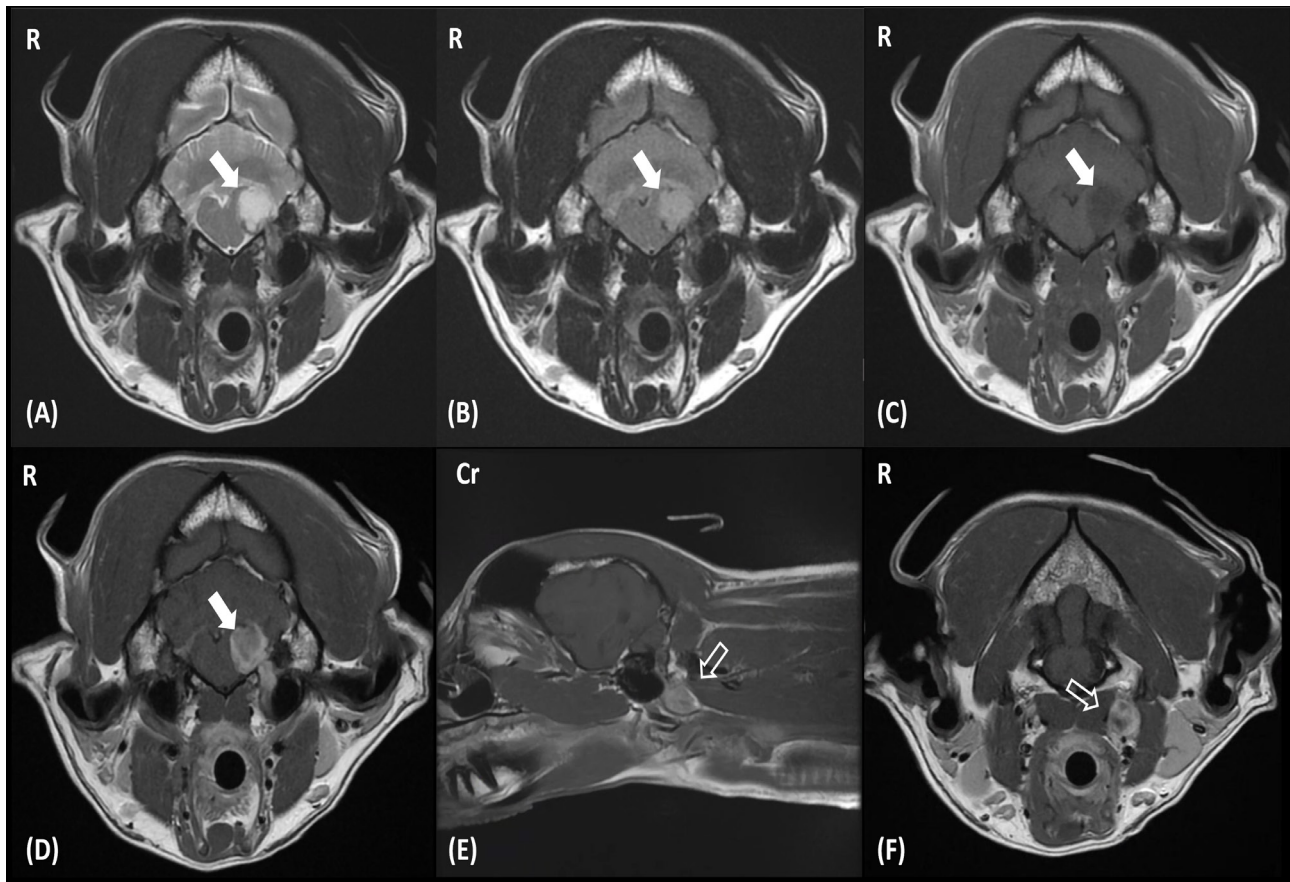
Magnetic resonance imaging of the intracranial and extracranial lesion. Left side corresponds to the right side of the patient. A well-demarcated mass (white arrows) was located at the left lateroventral region of the medulla oblongata and extended caudally and medially through the jugular foramen and tympano-occipital fissure, forming a tubular-shaped lesion. The lesion appeared hyperintense on T2-weighted (A) and FLAIR (B) images, hypointense on T1-weighted images (C), and showed overall moderate enhancement with more pronounced peripheral enhancement on post-contrast T1-weighted images (D-F). The extracranial portion of the mass (open white arrows) exhibited a well-demarcated, oval shape and displayed similar enhancement characteristics to the intracranial portion of the mass (E & F).
